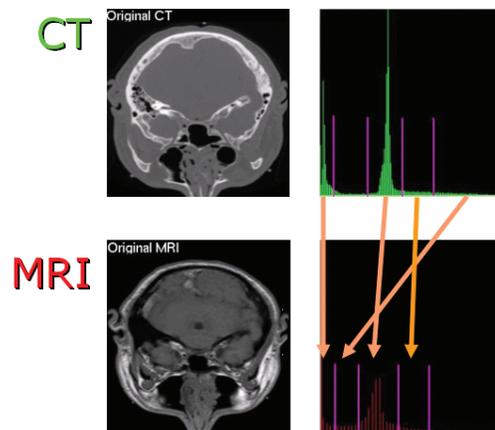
Mapping of CT histogram (green) onto MRI histogram (red). Bin boundaries are shown in purple color.
